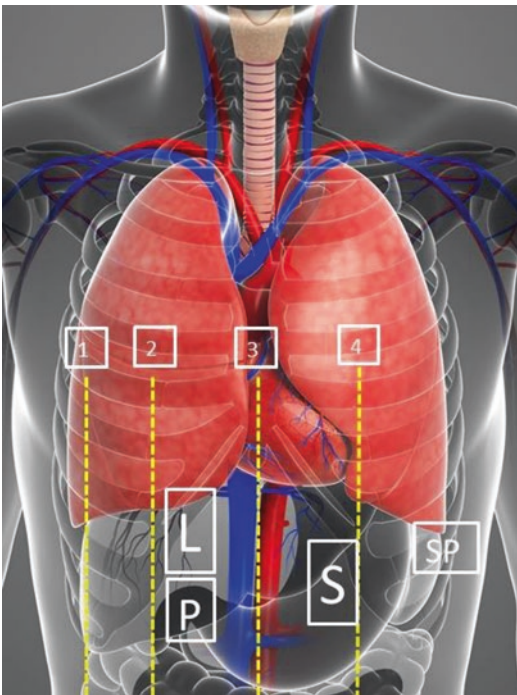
The organs of the upper abdomen that can be assessed by ultrasound; the transparency of the organs reflects the anteroposterior arrangement of the organs. The ultrasound planes from right to left include (1) right anterior axillary line, (2) right midclavicular line, (3) midline, (4) left midclavicular line. *L* liver, *S* stomach, *P* pylorus, *SP* spleen
